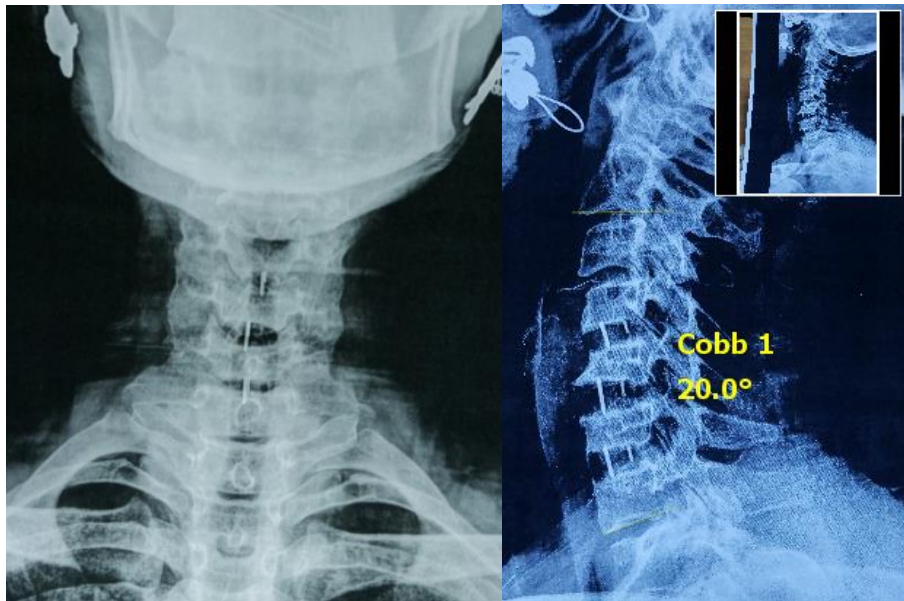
Postoperative X-ray AP and lateral view at 6 months Cobb angle 20°.
